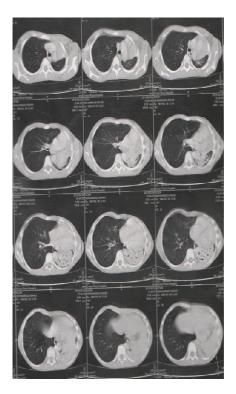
Mass in chest CT scan
